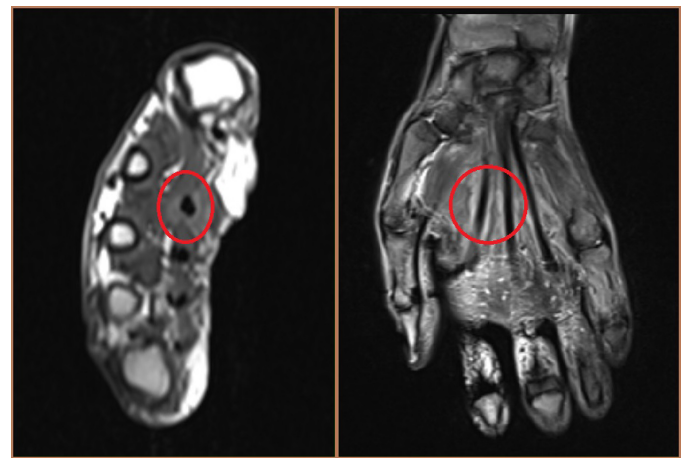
Magnetic resonance images showing minimal effusion around the flexor tendons (flexor digitorum superficialis and profundus) and minimal edematous signal changes in the surrounding soft tissues at the wrist level.
